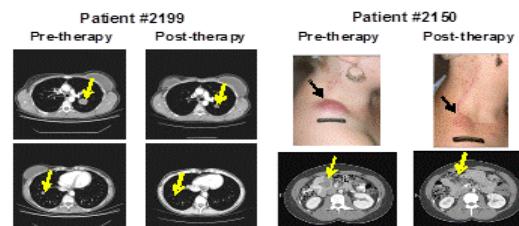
Pre- and post-treatment photos and CT scans of responding metastatic lesions in two ACT patients. Post-treatment analysis was done 12 weeks after TIL infusion. Patient #2199 received an autologous DC co-vaccine with multiple lung lesions responding partially or completely. Patient #2150 (no DC co-vaccine) had a complete response of subcutaneous and lymph node lesions. Arrows point to the respective lesions.
